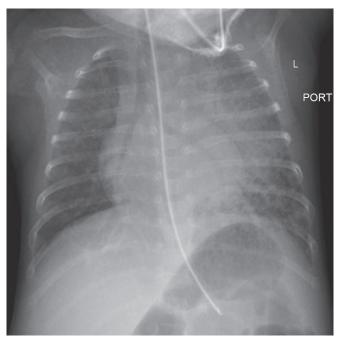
Chest X-ray of case 1 showing bilateral granular opacities, more on the left
